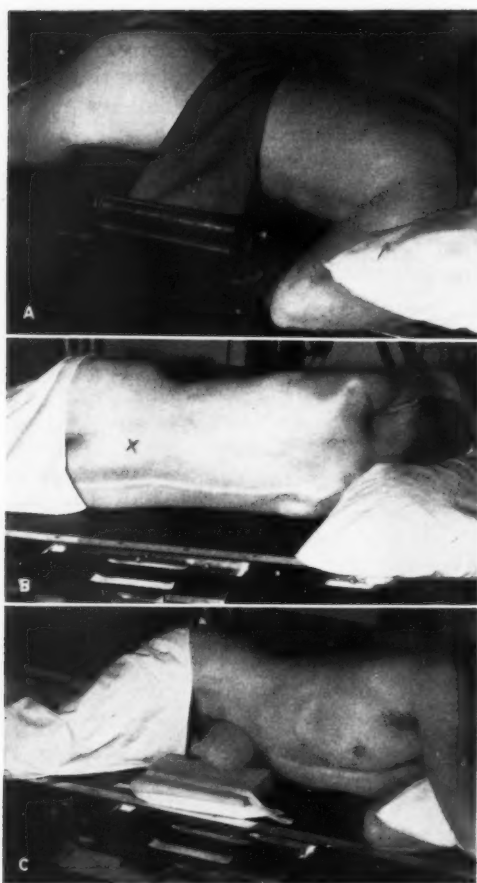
A. Correct positioning of patient on wedge-shaped cassette holder for venograms in the postero-anterior projection. X-ray tube must be tilted according to inclination of film. X indicates site of bone puncture.
